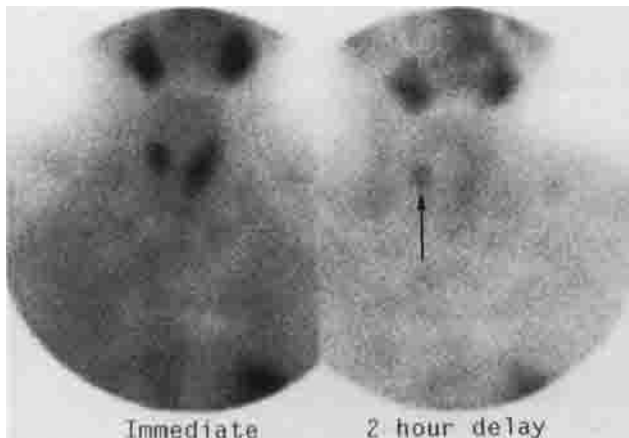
A 44-year-old male with primary hyperparathyroidism and prior right partial thyroidectomy for adenoma at age 21 underwent neck exploration in February 1995. No abnormal parathyroid glands were identified. Left neck exploration and local lymph node resection incidentally revealed a diagnosis of papillary thyroid carcinoma. Subsequently, the patient underwent ultrasound, CT, sestamibi scintigraphy, parathyroid arteriography, and parathyroid venous sampling. The ultrasound and CT did not identify an abnormal parathyroid gland. The ^{99m}Tc sestamibi scintigram (shown) was consistent with a parathyroid adenoma in the right neck (arrow).
